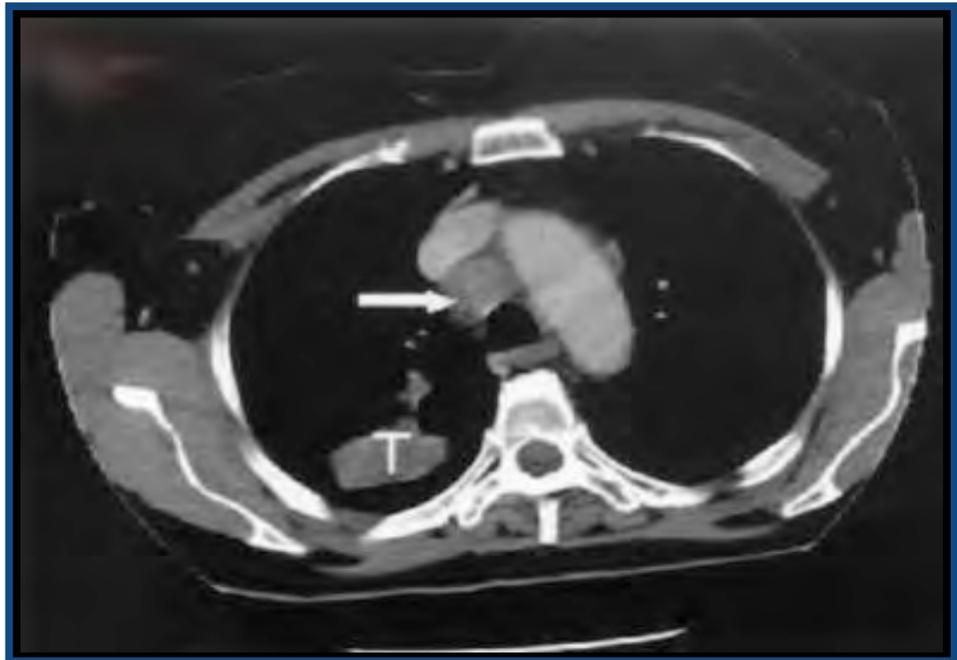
Chest CT Scan Showing a Tumor with Lymph Node (arrow) Involvement in a Location that Defines this as Stage III Disease.
